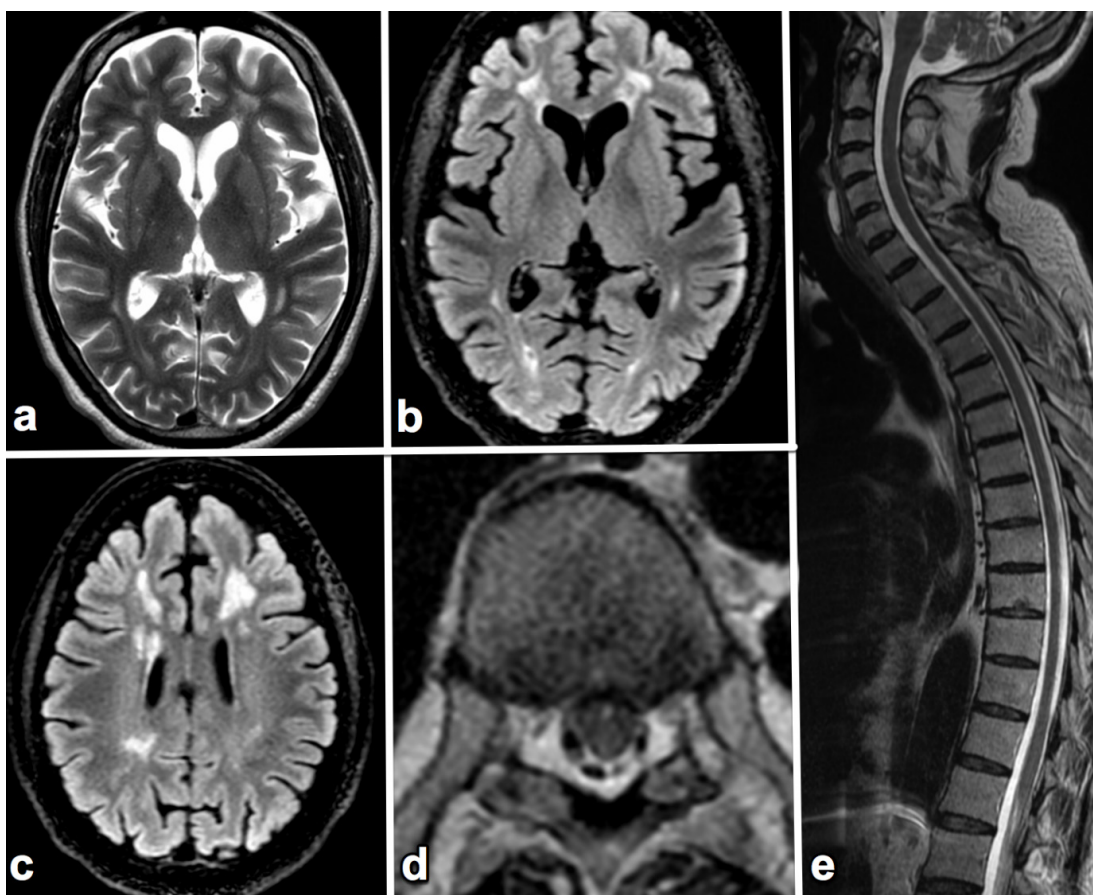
Follow imaging after 18 months. MRI Brain: Axial T2 (a) and FLAIR (b, c) images show partial resolution of T2/FLAIR hyperintensities with volume loss in deep and periventricular white matter of bilateral frontal, parietal and posterior temporal region. MRI spine show complete resolution of posterior column hyperintensities on axial (d) and sagittal (e) T2- weighted image
